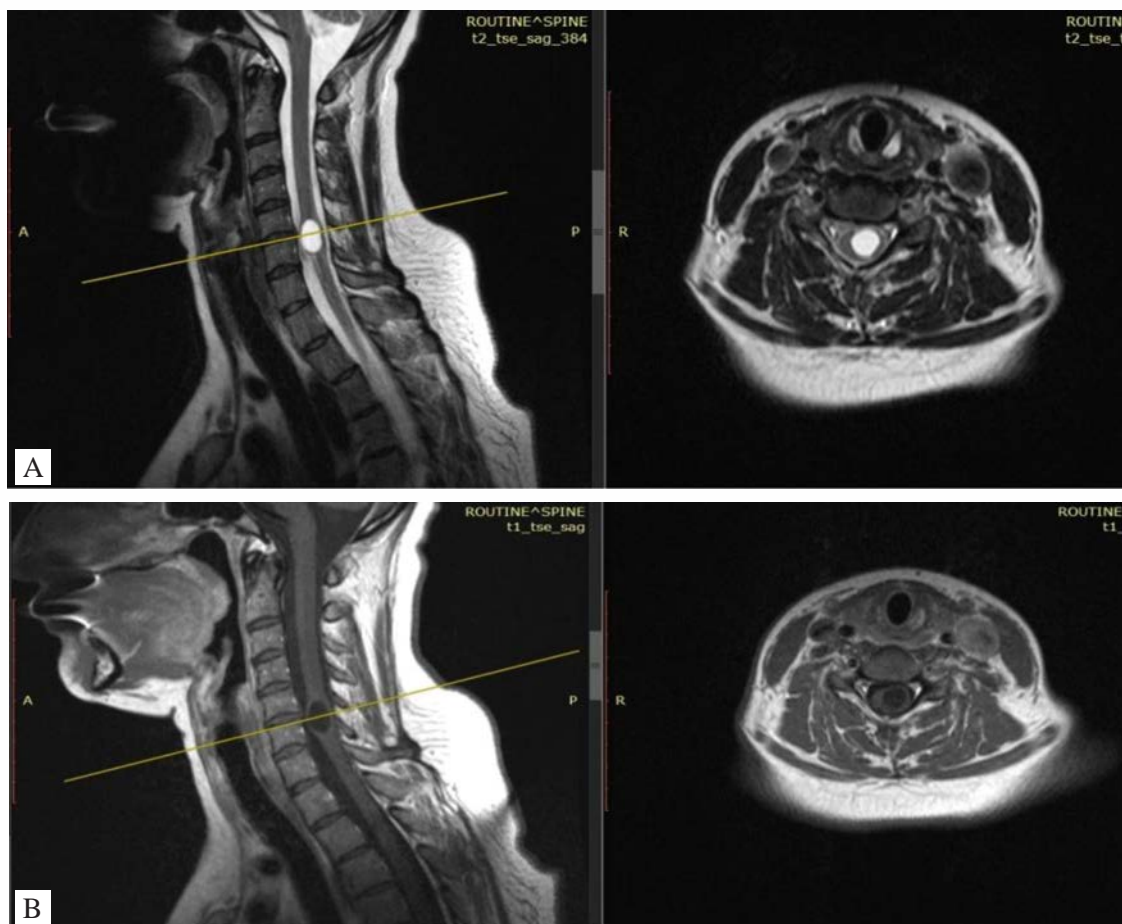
Preoperative MRI of the cervical spine: A,B – mode T1; B,C – mode T2 with contrast.
